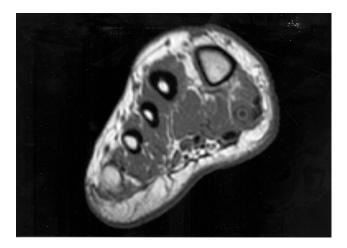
T1-weighted axial foot MRI depicting foreign body as a target appearance similar to flexor hallucis brevis tendon.
